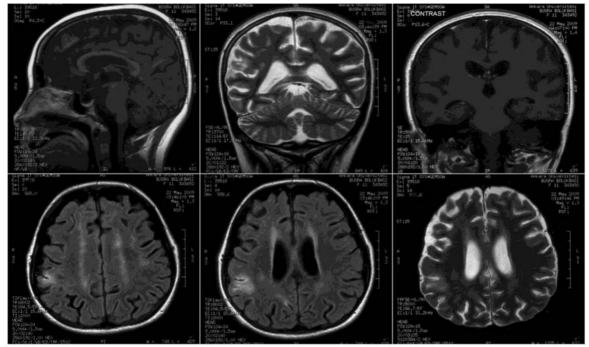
Magnetic resonance imaging (MRI) findings at admission.
